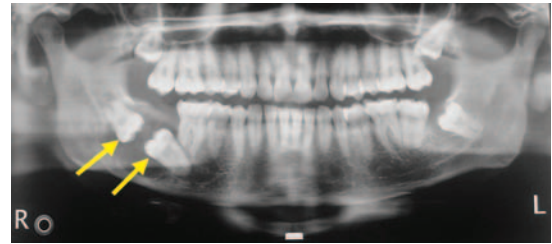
Radiograph showing mandibular third molar erupting from the inferior border of mandible. Patient presented with chronic discharging sinus in the left submandibular region. The impacted tooth was removed under general anesthesia by submandibular approach.
